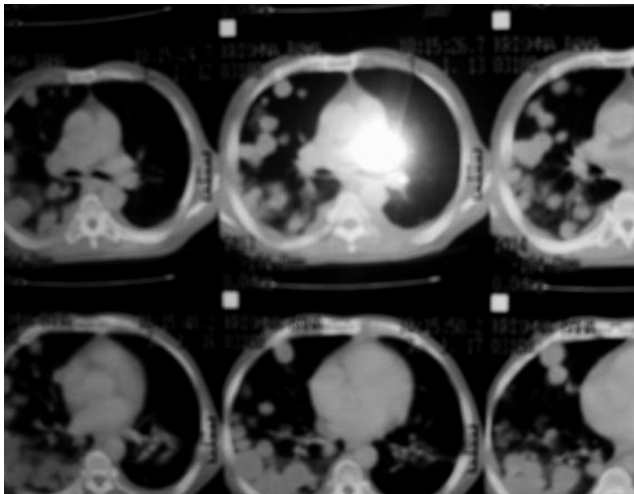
CT scan reported as metastasis
